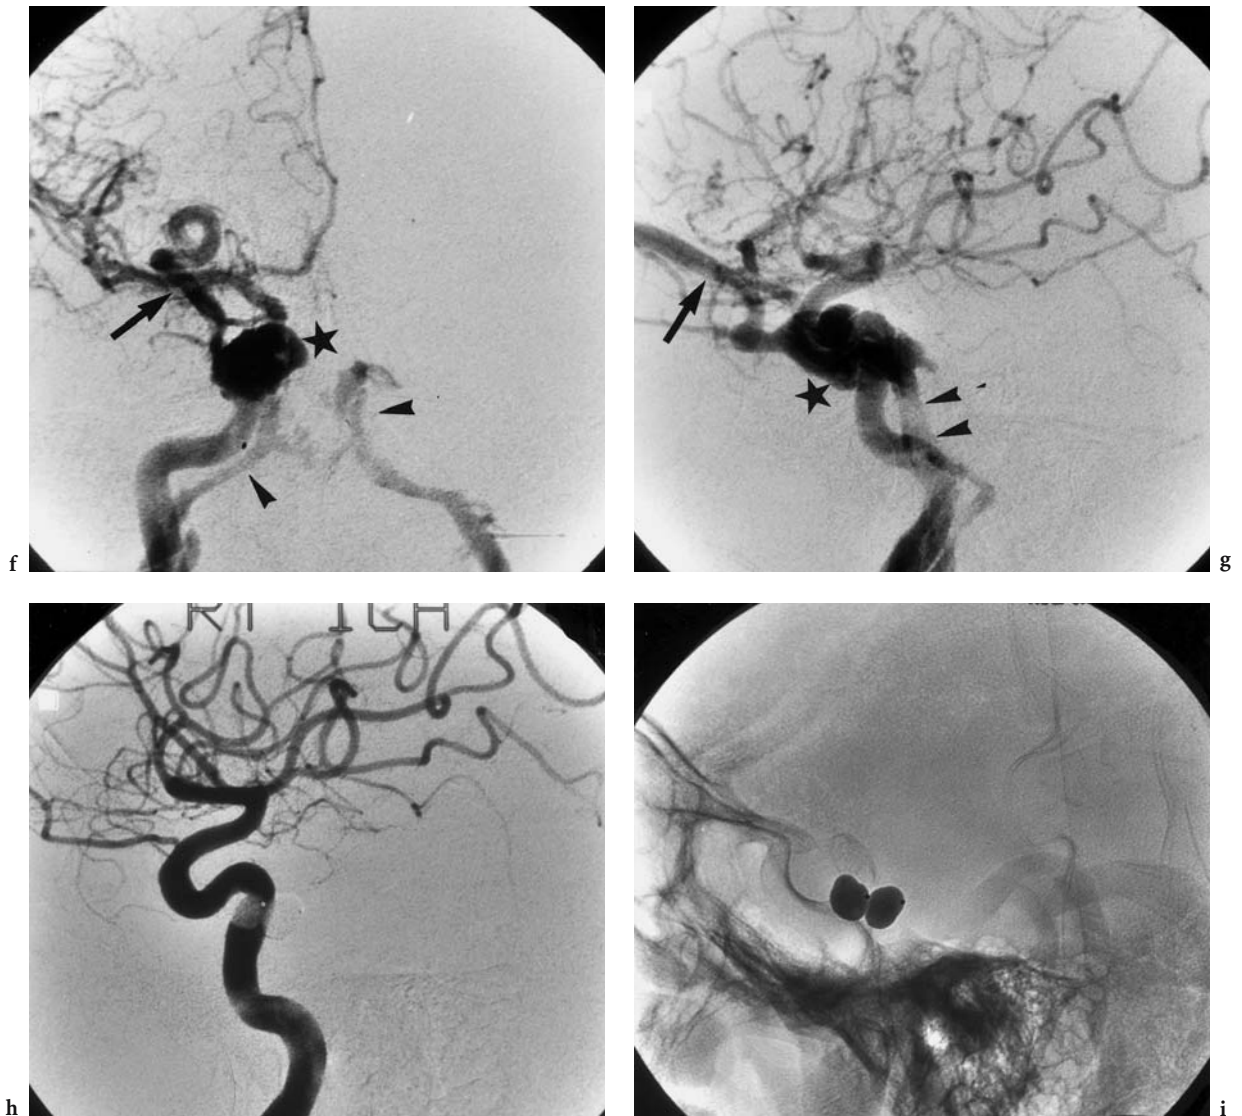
A 54-year-old man with spontaneous blurred vision and painless, but progressing proptosis of the right eye (5 mm in 4 weeks), in addition to chemosis, proptosis, and a (subjective and objective) pulsatile bruit over the right orbit. Diagnosis: high-flow CCF. MRI: a Axial T1-weighted native view at the level of the optic nerve, showing only mild proptosis, but initial enlargement of the right external muscles compared to the left. b Axial T1-weighted view of the upper orbit with extreme widening of the right superior ophthalmic vein. c Coronal T1-weighted view identifying the different lumen of the... ▷
